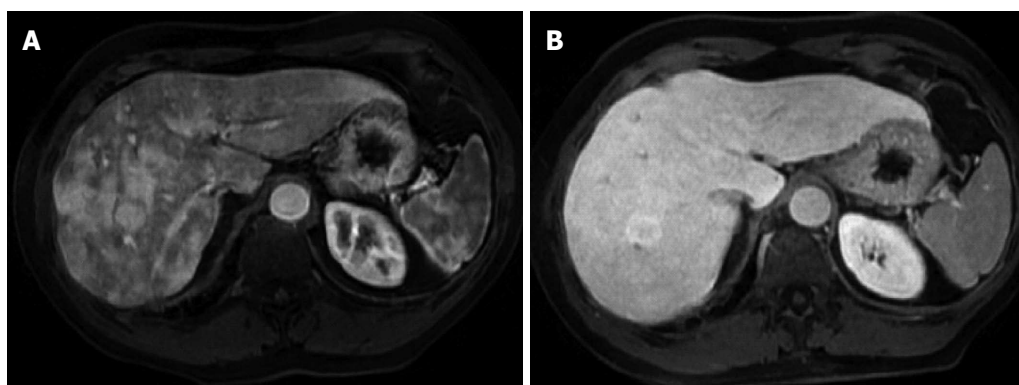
Magnetic resonance. A: Fat saturation gradient echo T1-weighted hepatic arterial phase magnetic resonance (MR) shows multiple ill defined hypervascular areas in the the right liver lobe, due to arteriovenous shunts, and a round, clearly visible, 3 cm lesion surrounded by a hypointense halo; B: On hepatobiliary phase MR, arteriovenous shunt are no longer visible, while lesion, proven to be focal nodular hyperplasia at core biopsy, is hyperintense in comparison to surrounding liver parenchyma.
